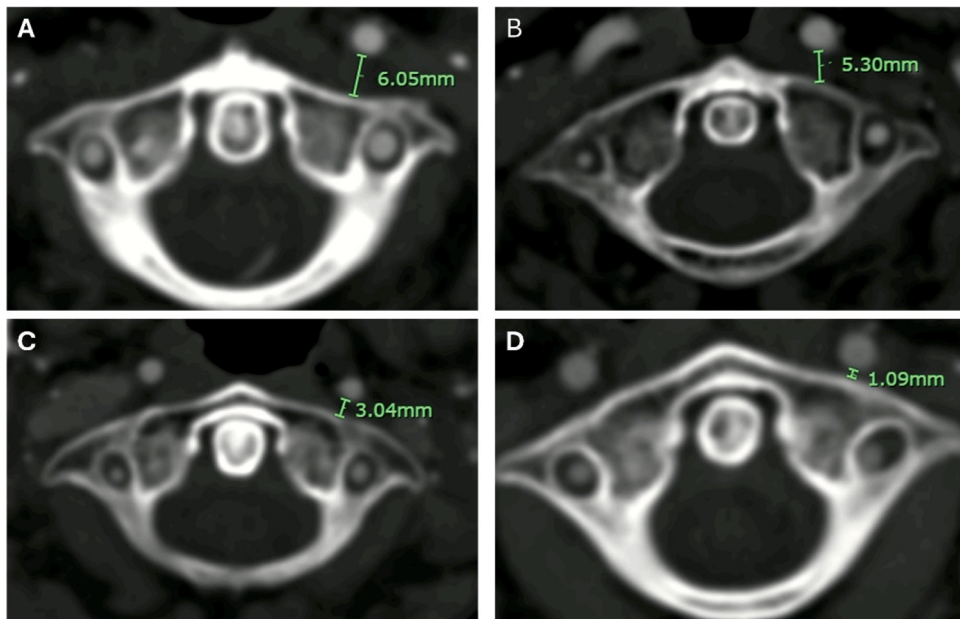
Representative axial CTA images demonstrating the ICA injury risk categories: none (A), low (B), moderate (C), and high (D).
